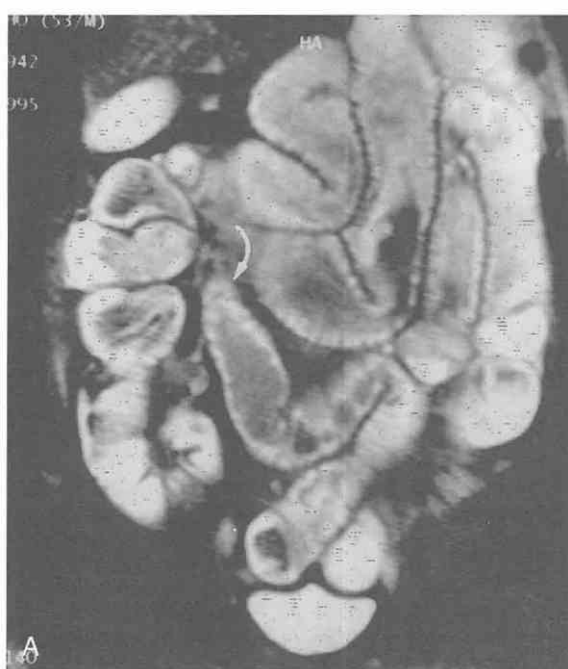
Simple intestinal obstruction caused by bowel adhesion. *A*, Coronal half-Fourier acquisition single-shot turbo spin-echo (HASTE) MR image shows diffuse small-intestinal loop dilatation with tapered luminal narrowing at the obstructed site (arrow). *B*, CT scan shows end-on view of a narrowed intestinal segment (arrow) just above the obstructed site.
